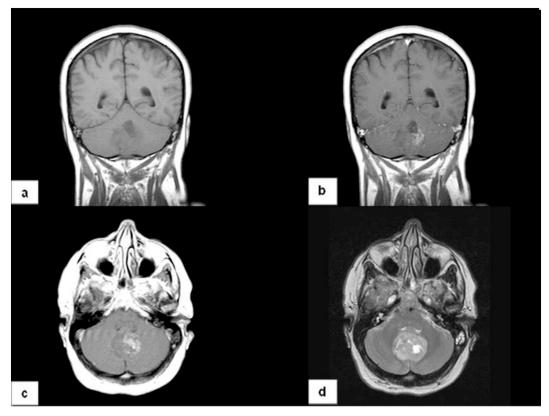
The T1-weighted coronal sequence (a) shows an inhomogenously hypointense midline tumour of the posterior fossa. T1-hyperintense signal indicating fatty content was not detected. The lesion enhances gadolinium inhomogenously (b, c). Note the hyperintense signal of the tumour on T2-weighted sequence (d) and the regressively altered portions with almost fluid-equivalent T2 and T1 signal.
